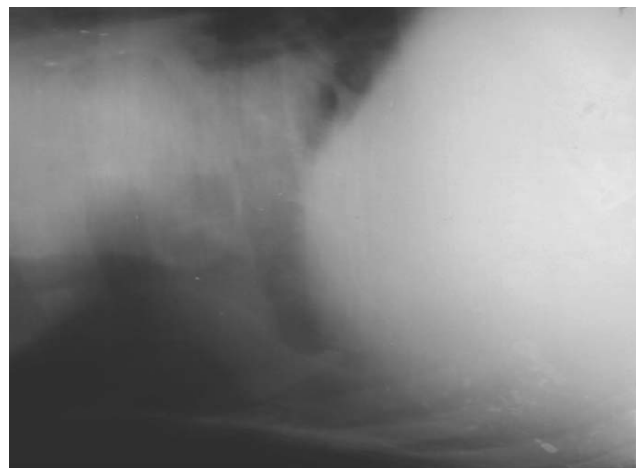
Left lateral radiograph showing indistinct line of diaphragm
